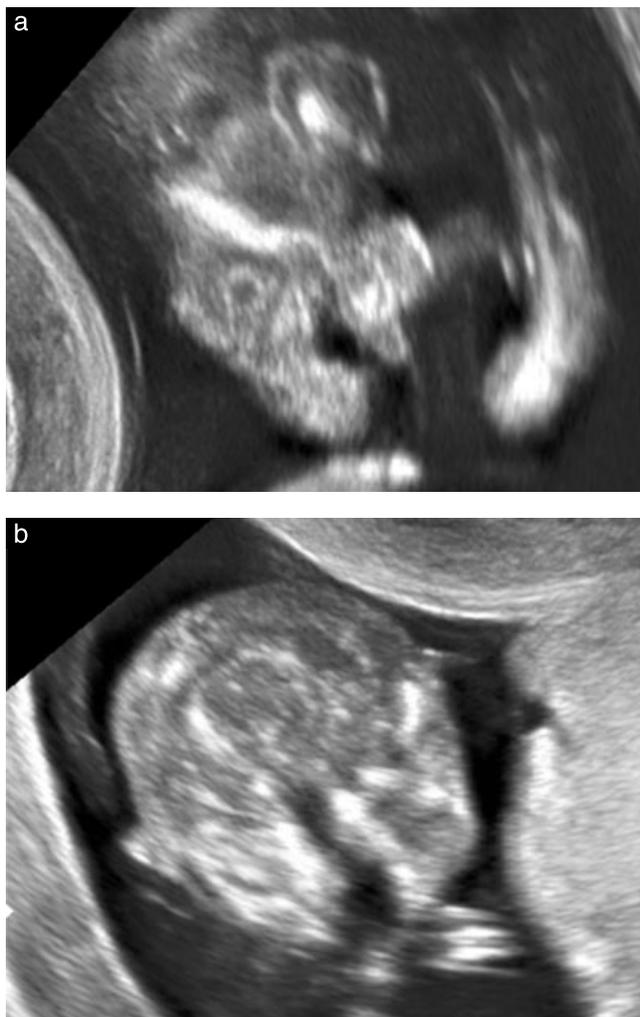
Transvaginal sonography in a first-trimester fetus with unilateral cleft lip and palate and associated encephalocele. Coronal (a) and transverse (b) views of the fetal palate showing severe orofacial clefting. Note the abnormal configuration of the retronasal triangle in the coronal view.
